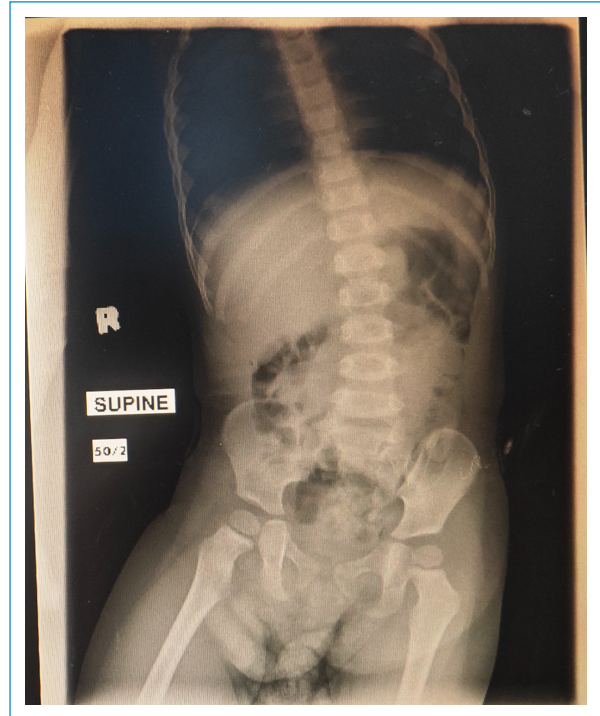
Abdominal radiograph at 19 months of age.
